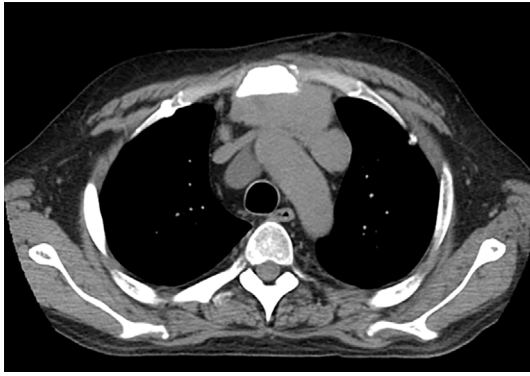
Chest computed tomography (CT) on admission showing an 8-cm-sized tumor in the anterior mediastinum.
